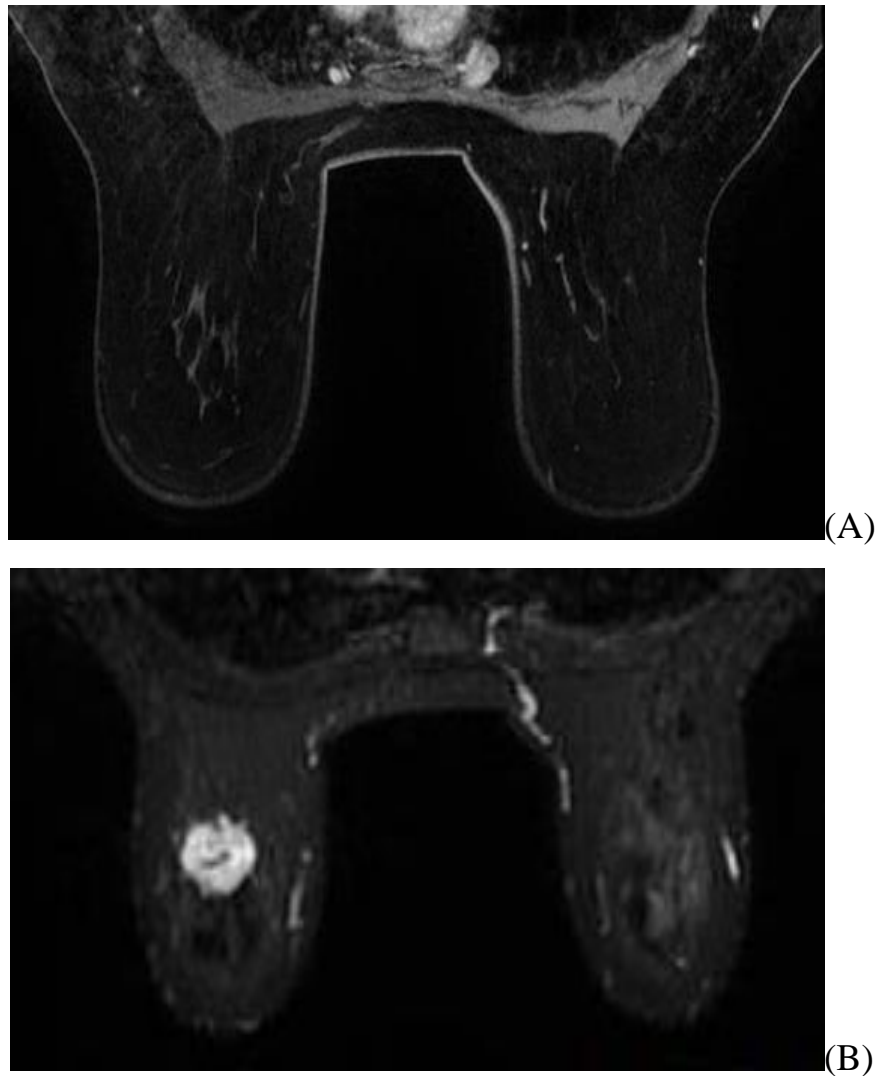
(A)Normal MRI breast, (B)hyperintense lesion
